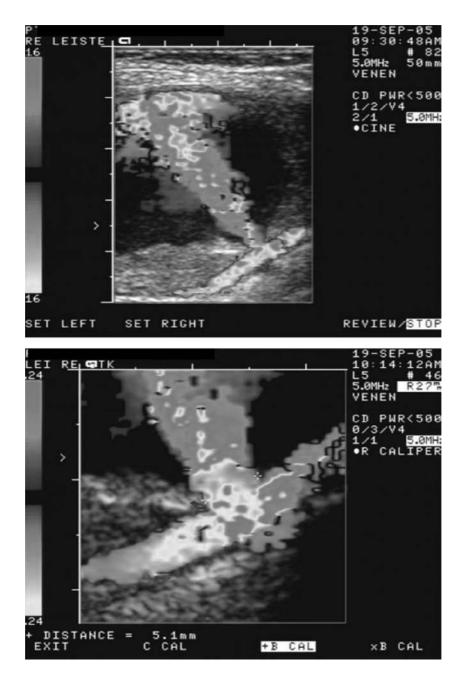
Duplex sonography of an iatrogenic pseudoaneurysm in the common femoral artery with a central jet (upper image) and a wide neck (lower image).
